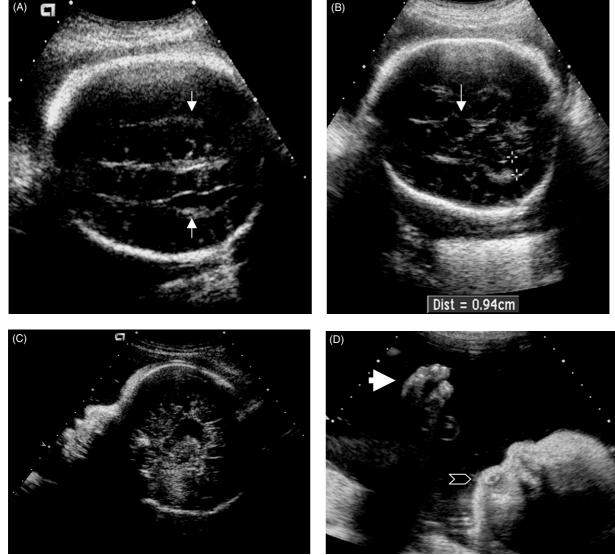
Prenatal ultrasound images of patient 2 at 35 weeks. (A) Axial view through the fetal head showing parallel lateral ventricles (arrows) with teardrop shape characteristic of agenesis of the *corpus callosum*. (B) Axial view through the fetal head at the plane of the biparietal diameter showing oblong cranial shape, dilated high rising third ventricle (arrow) and lateral ventricle measurement at the upper limit of normal for gestational age (calipers). (C) Fetal profile (midline sagittal view) showing frontal bossing and depressed nasal bridge. Cerebral sulci are seen radiating from the roof of the third ventricle. (D) Axial views through left hand and fetal head. Arrow indicates cross-sectional view through the digits of the left hand. Despite fetal movement distal digits including the thumb remained in constant apposition consistent with soft tissue syndactyly. Open arrowhead indicates prominent orbit (with lens visible)
